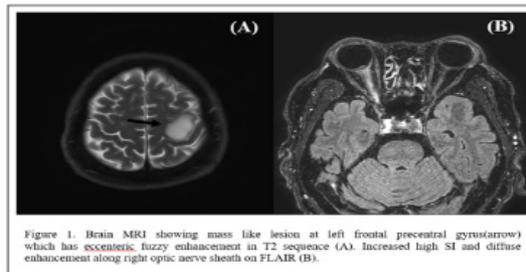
Brain MRI showing mass like lesion at left frontal precentral gyrus(arrow) which has eccentric, fuzzy enhancement in T2 sequence (A). Increased high SI and diffuse enhancement along right optic nerve sheath on FLAIR (B).
